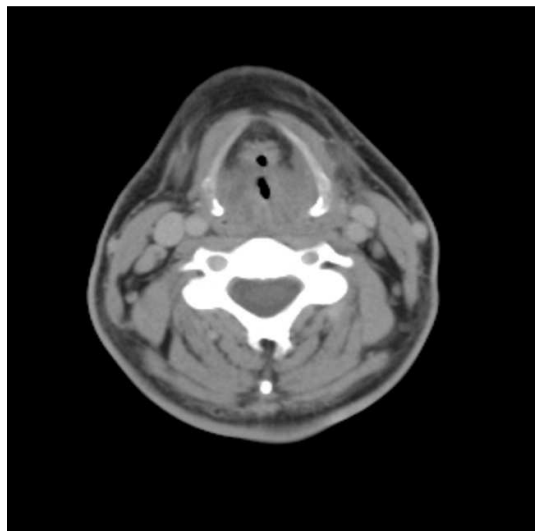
CT neck shows circumferential soft tissue infiltration at the level of false vocal cord. Marked airway luminal compromise also seen.
